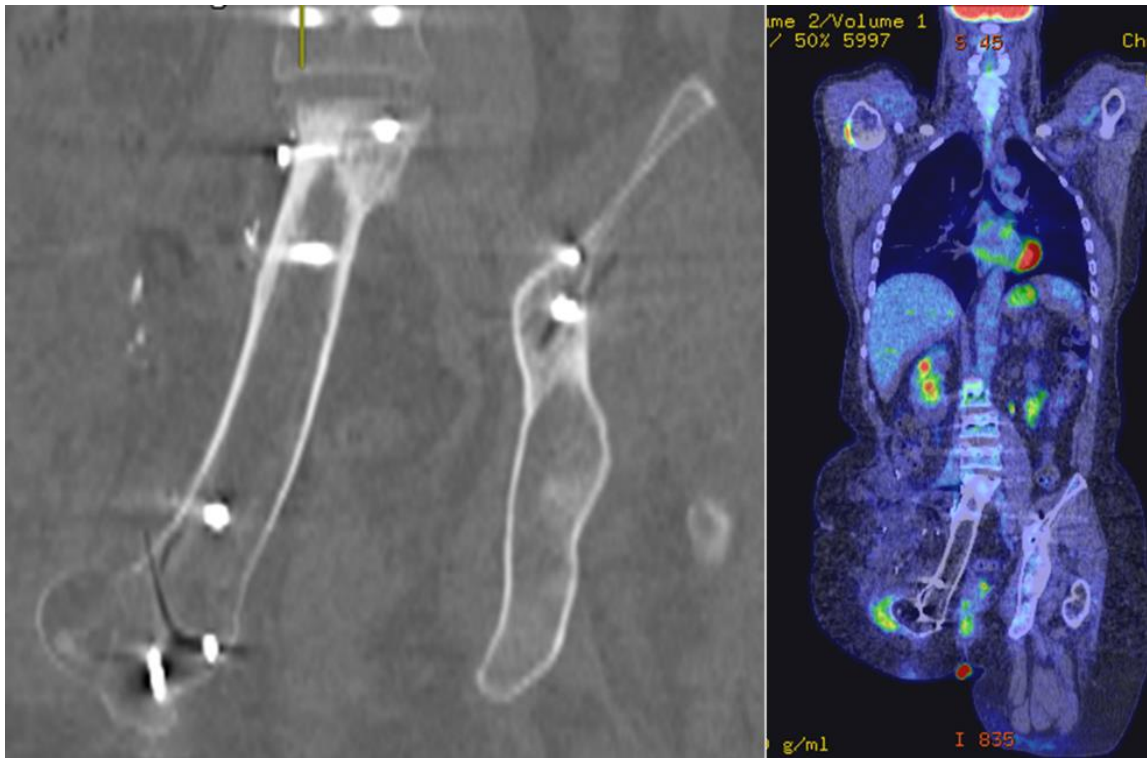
Postoperative computed tomography (CT) scan demonstrating fusion of vascularised femoral autograft, and postoperative PET scan showing no active disease
